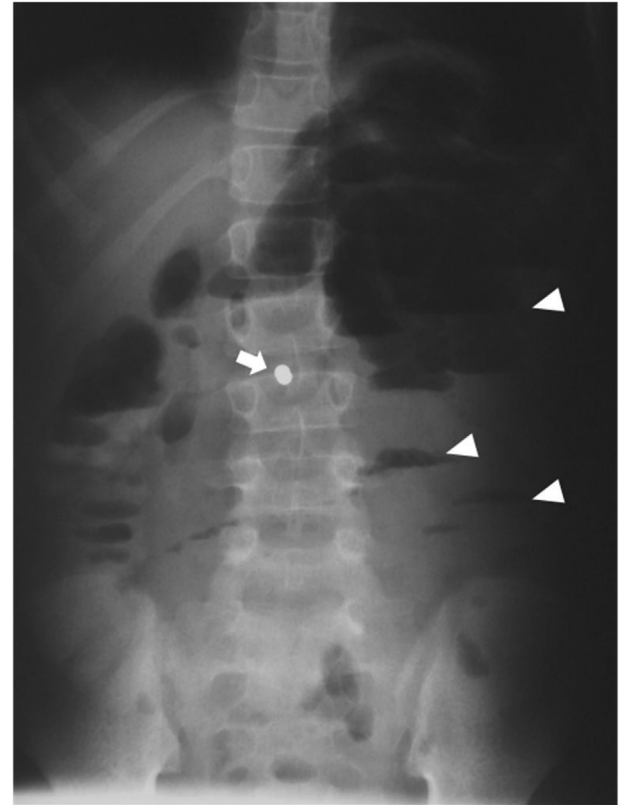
Follow-up abdominal radiograph showing slight movement of the radiopaque foreign body (arrow) without significant progression into the ileum. Note established small bowel obstruction with multiplication of air-filled jejunal and ileal loops containing air-fluid levels (arrowheads) and persistent paucity of bowel gas distally.
